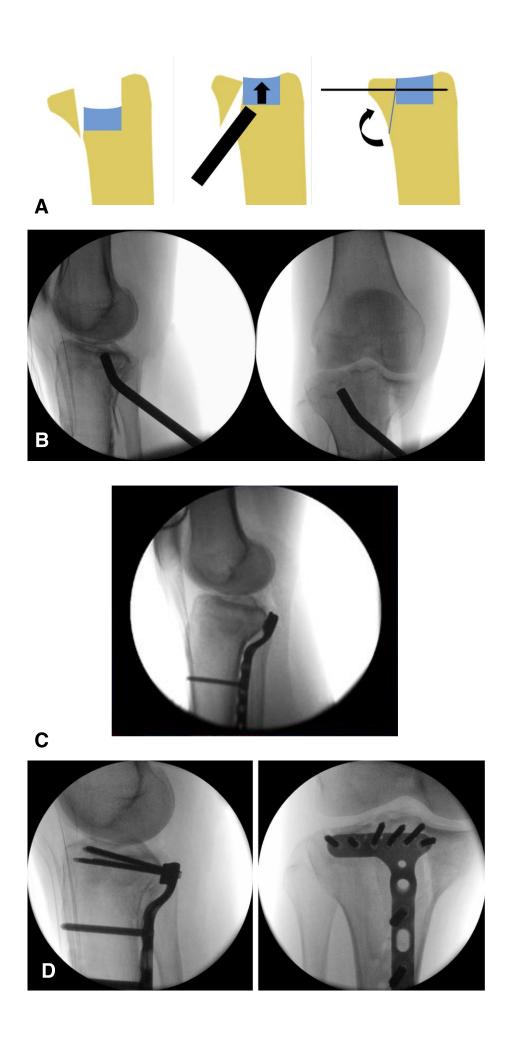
Indirect reduction technique and WAVE posterior proximal tibia plate application. If buttress alone is not enough, first attempts can be made to reduce an associated articular depression by folding away the posterior fracture fragment (or opening the posterior cortex using a saw or drill) and inserting a plunger. (A, B) A posterior arthrotomy is not necessarily required. After reduction, posterior fracture fragment(s) are temporary fixated with K- wires and the reduction is verified using fluoroscopy. This buttress plate osteosynthesis starting with a large fragment cortical screw that will pull the plate to the bone and (further) reduce and restore the posterior wall. (C) Proximal locking screws (small fragment) are inserted in order to provide sufficient articular support. Depending on the need for further articular reconstruction of the existing extended lateral (or medial) column fractures, it can be decided not to use (all) the proximal locking screws. After application of the WAVE posterior proximal tibia plate fluoroscopy shows adequate reduction. (D) Articular congruence can be hard to evaluate intraoperative, therefore dry arthroscopy (i.e. fracturoscopy) or intraoperative CT might be beneficial here.
